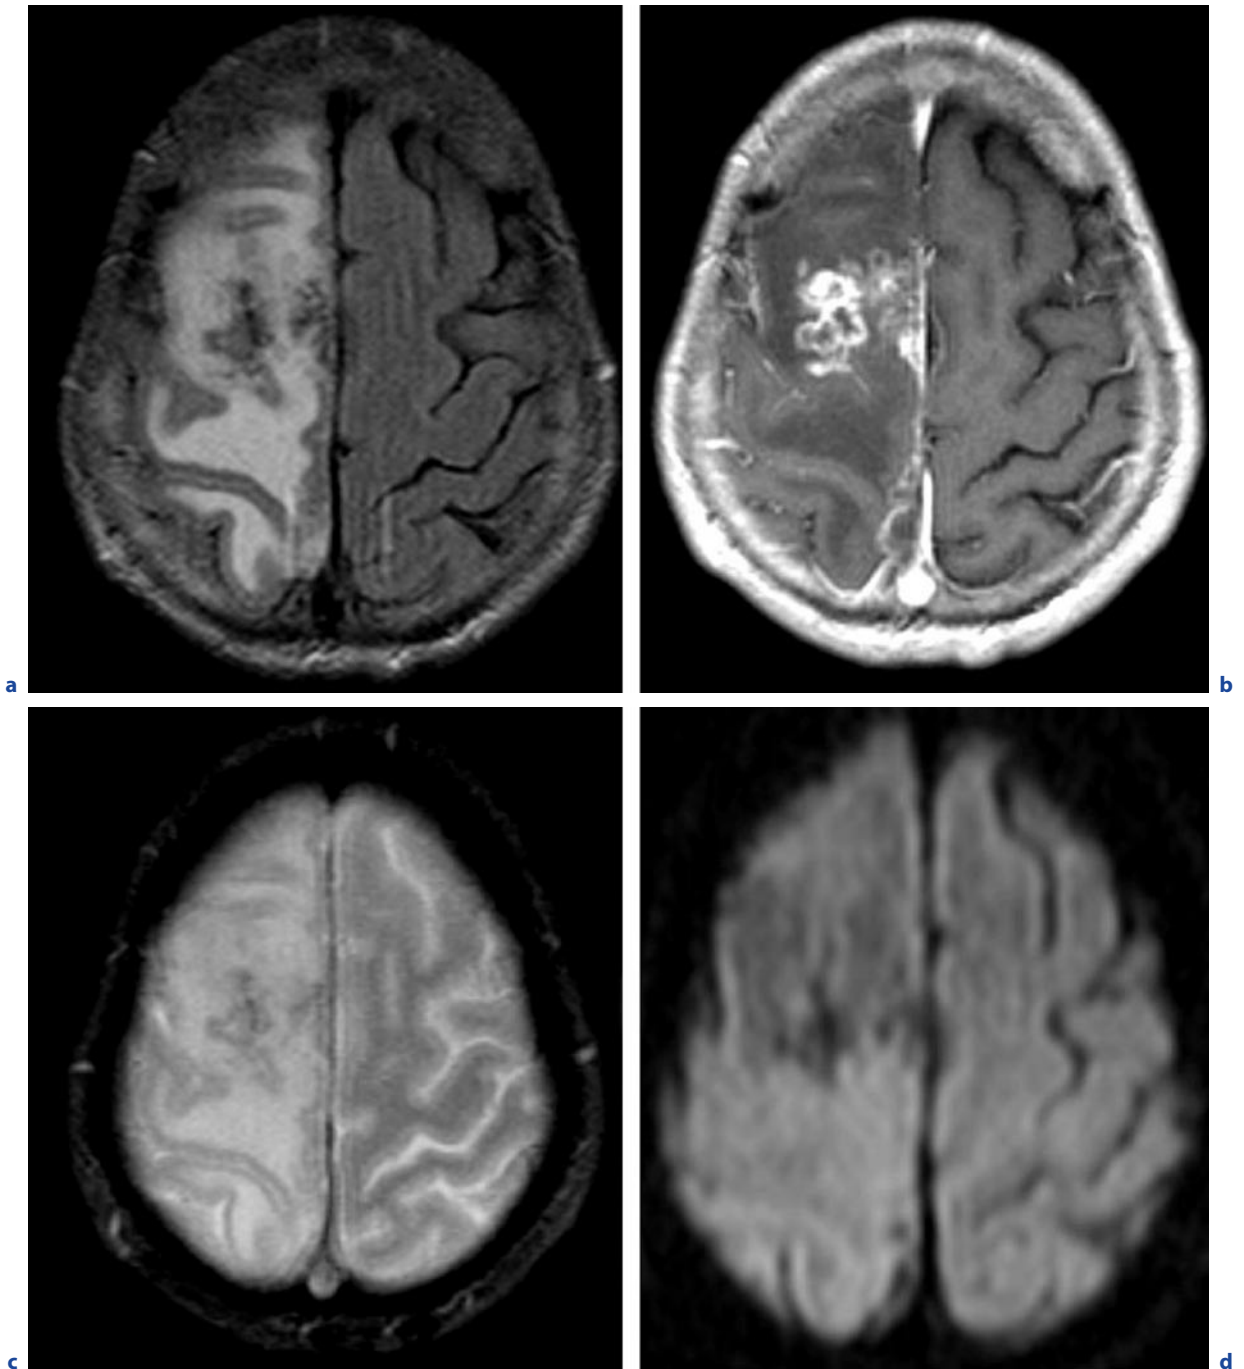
Cerebral alveolar echinococcosis. a Axial FLAIR image. b Axial T1-weighted image after contrast administration. c Axial T2*-weighted image. d Axial DWI. The right frontal lesion is space occupying and appears inhomogeneous on T2-weighted images (a) with a mixture of hyperintense and hypointense areas, the latter correlating mainly to calcifications
